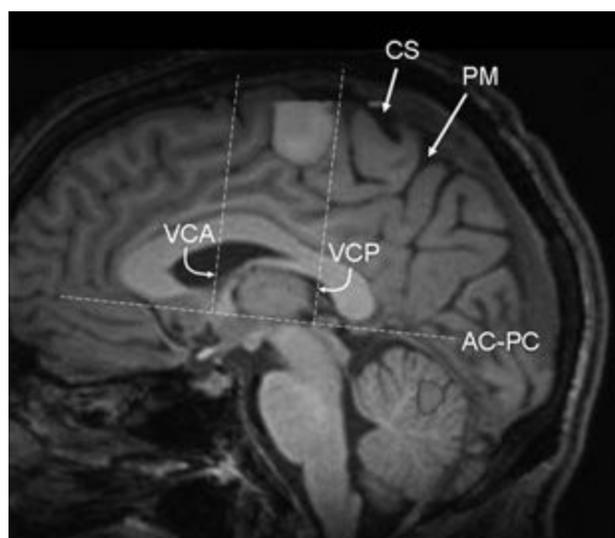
Functional MRI using a finger-tapping paradigm (paramedian sagittal plane) shows activation of the supplementary sensorimotor area (SSMA), which lies within the paracentral lobule and is located anteriorly to medial margin of the central sulcus. In addition, cerebellar activation is also present. Note the anatomical relationships of the SSMA to the AC–PC line, as described in the paragraph on Supplementary Motor Area, above. The border between the pre-SSMA anteriorly and SSMA proper corresponds to the VAC line, and the border between SSMA proper and PMA posteriorly corresponds approximately to the VPC line. AC–PC refers to
